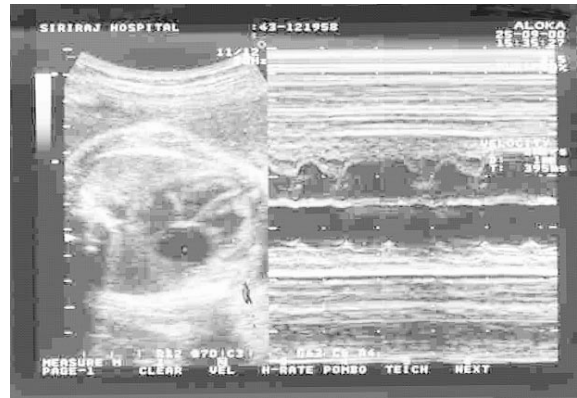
Two dimensional echocardiogram and M-mode imaging of a fetus with second degree atrioventricular block, Mobitz I
